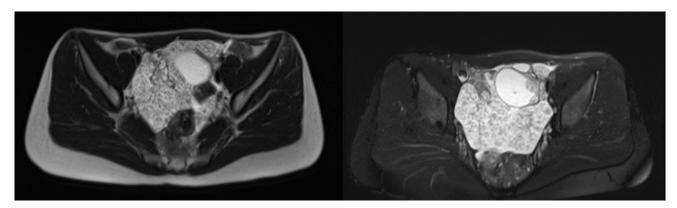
Axial T2-weighted MR image (left) and axial fat suppressed T2-weighted MR image (right) shows large pelviabdominal multilocular complex cystic lesion.
